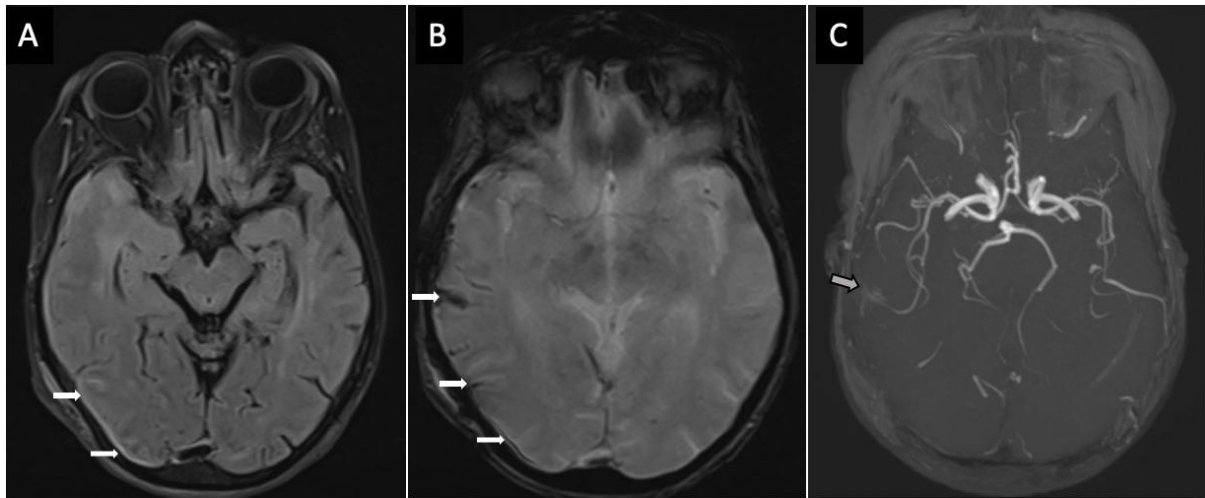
Brain MRI showing signal abnormalities in the right peri-temporal subarachnoid space with hyper-intensity on FLAIR sequence (A) and hypo-intensity on T2*-weighted gradient-echo (B). The TOF sequence (C) shows evidence of haemorrhage without aneurysmal lesions
